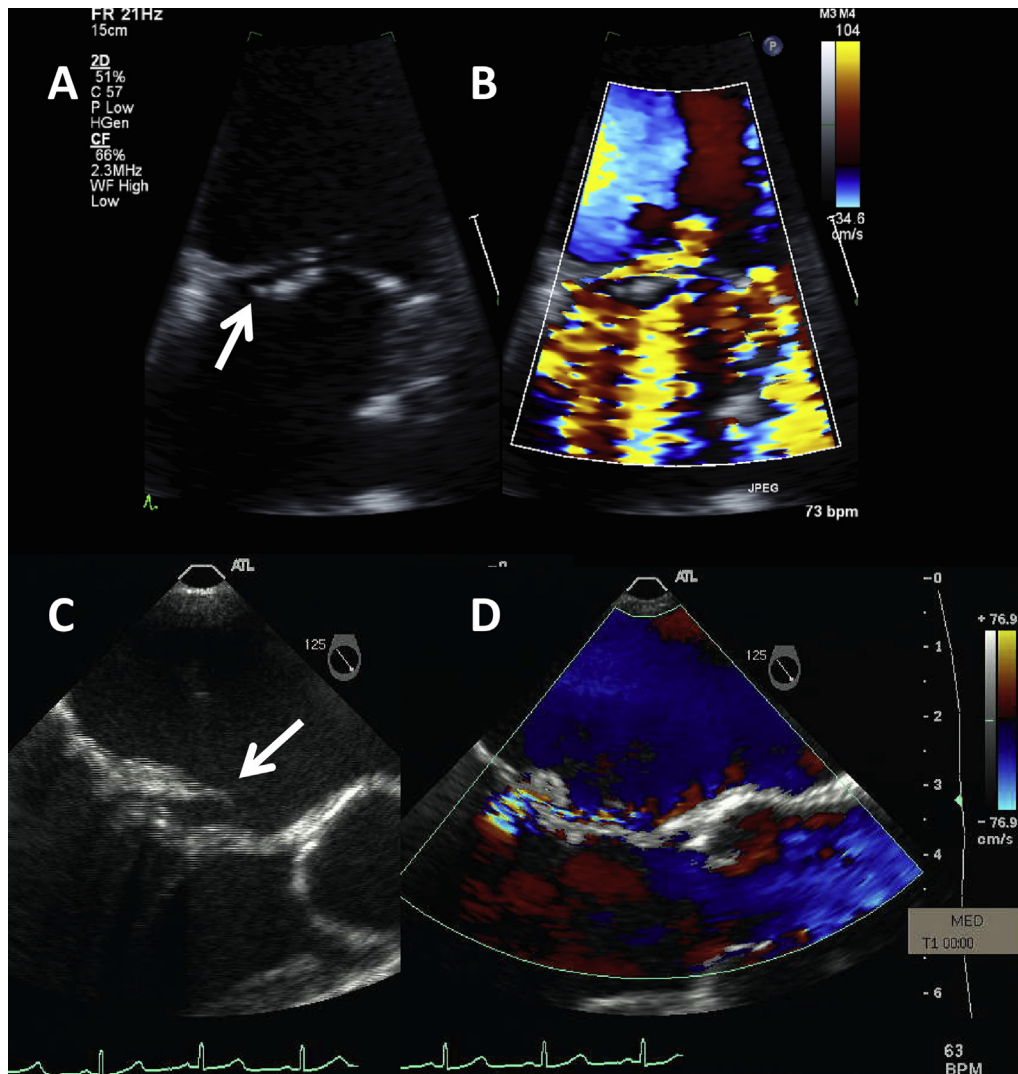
Representative case (case 11, Tables 1–3) of a flail mitral leaflet with moderate MR. (A) Apical four-chamber view on TTE displays a flail posterior leaflet (*white arrow*). (B) Color Doppler reveals an eccentric MR jet with a PISA radius consistent with moderate MR. (C) TEE performed on the same patient confirmed a flail posterior mitral leaflet (*white arrow*) with color Doppler features (D) consistent with moderate MR.
